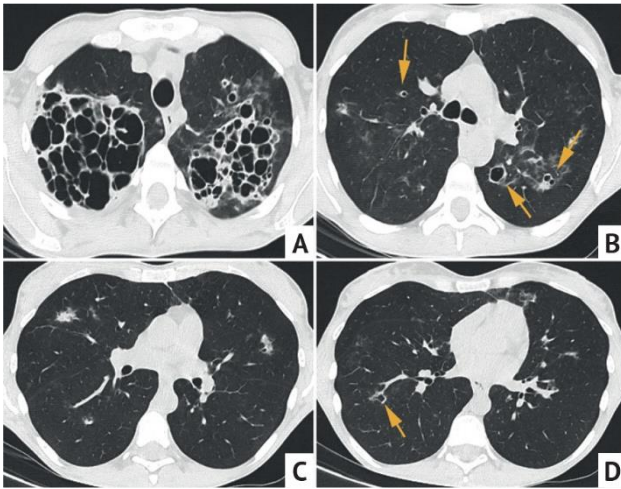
Axial chest CT images of 42 y.o patient (A–D), HIV, candidiasis of the esophagus. In addition to large multi-chamber cavities in the upper lobes (not typical for SPE), in other parts of the lungs, small thin-walled cavities with clear contours (arrows), small infiltrates are determined. Growth of *Candida*, *Aspergillus* fungi in the lavage fluid during bronchoscopy
